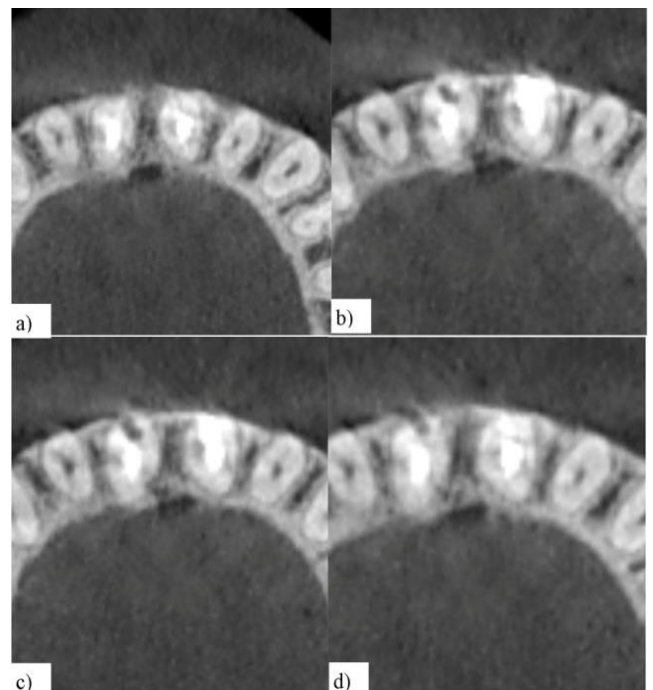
Transverse sectional images of a CBCT scan through tooth UR1 (a-d) from apical to coronal direction.
